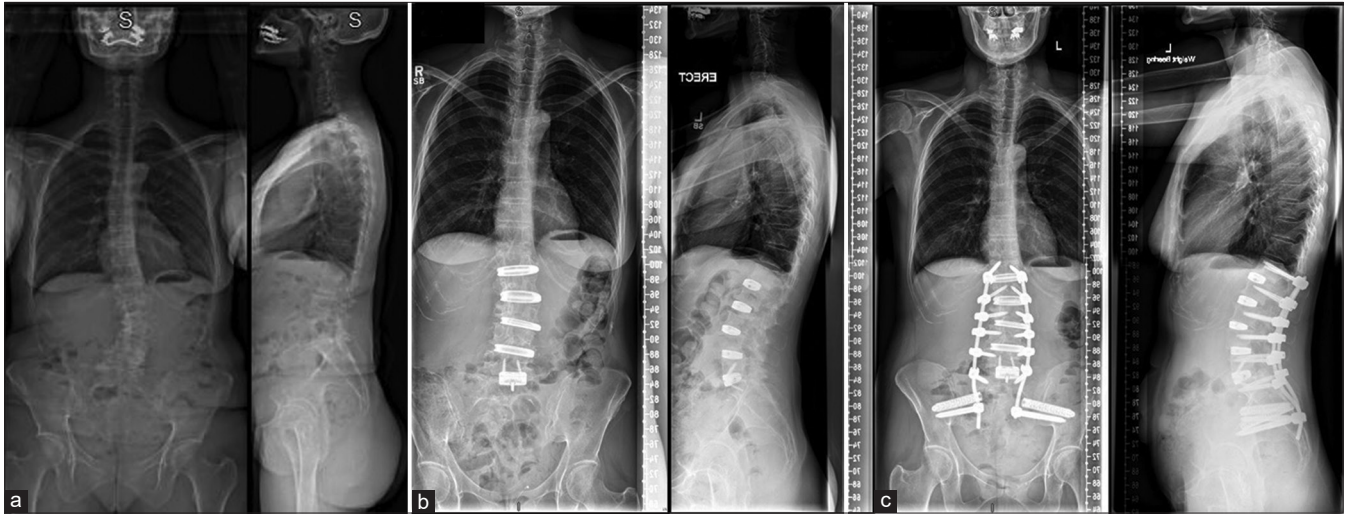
X-rays of patient: (a) preoperative image of the patient showing adult degenerative scoliosis deformity. (b) Postoperative images after Stage I showing deformity correction with multiple oblique lumbar interbody fusions and anterior lumbar interbody fusion at L5-S1 level. (c) Postoperative images after Stage II showing posterior L1 to pelvis fixation.
